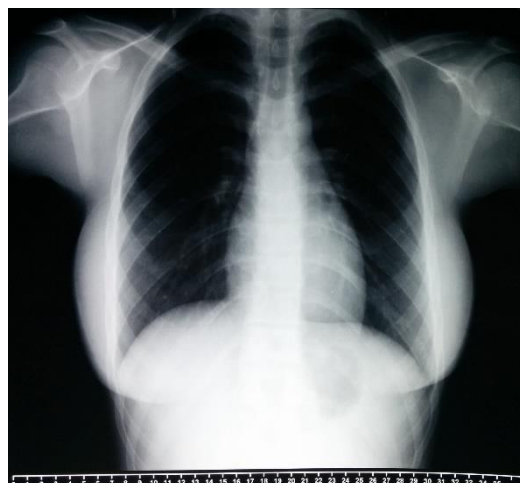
Chest x-ray showing no pulmonary lesions
